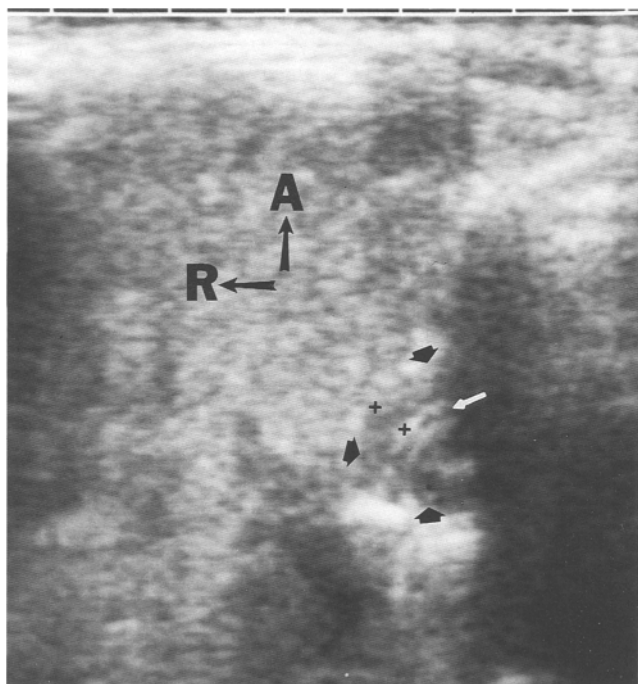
Patient JP – 1 month of age, vomiting since birth. UGIS normal; ultrasound showed transient pyloric thickening (*arrowheads*; one wall {between +3} = 4 mm) without significant elongation. Diagnosis pylorospasm. Vomiting resolved over 4 weeks. *White arrow* marks the pyloric lumen. *Arrows* point anteriorly (*A*) and rightward (*R*) for orientation
